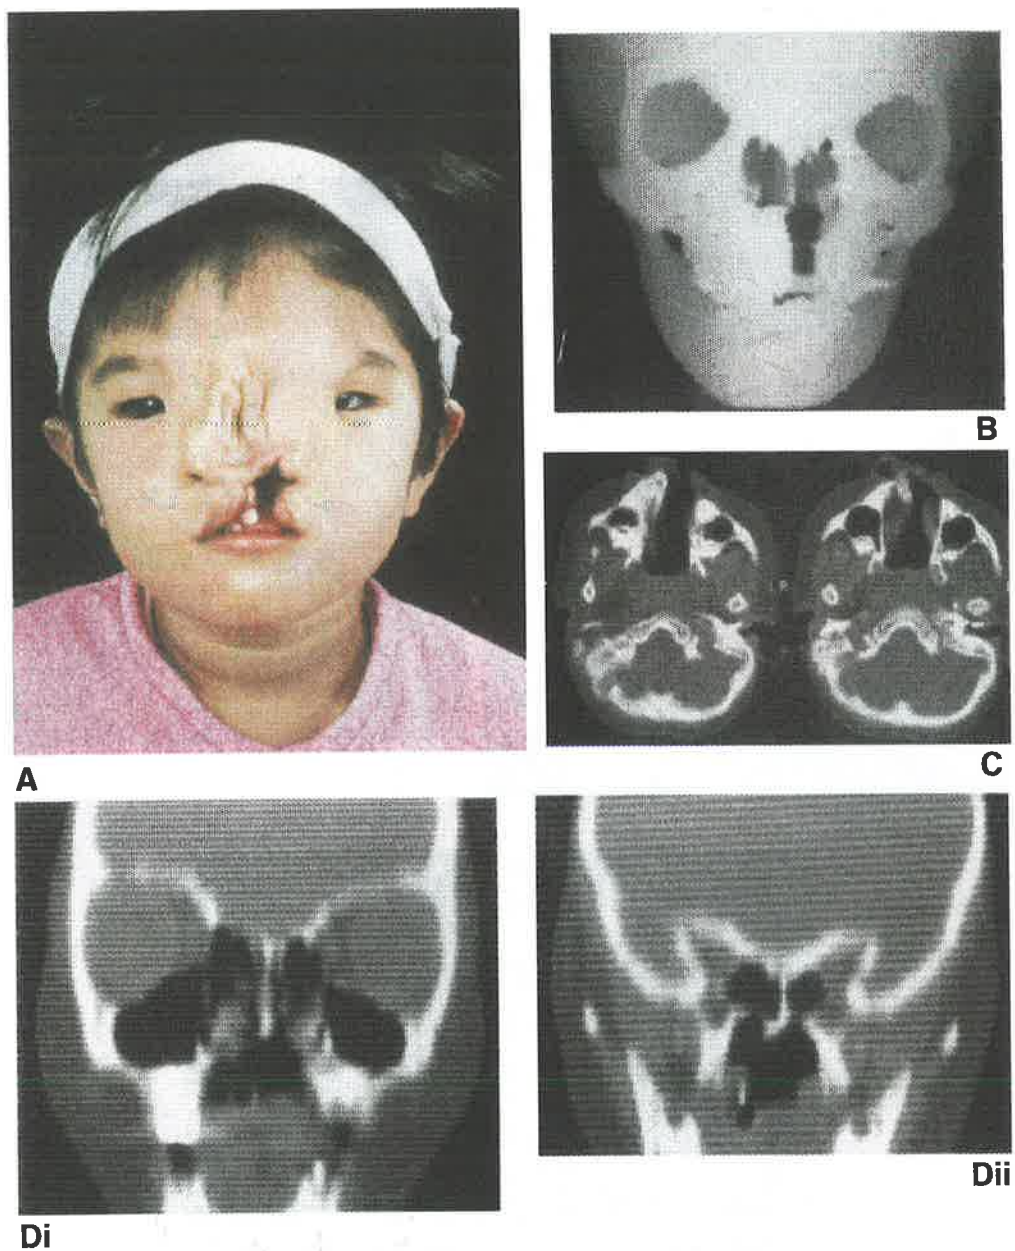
A. Four-year-old Malay Chinese girl with left-sided craniofacial clefts of the Tessier Number 1-13 type. B. Alveolar clefting between the central and lateral incisor extends into the pyriform margin. C. Normal septation between the nasal cavity and the hypoplastic cleft maxilla. D. Coronal two-dimensional CT reformats confirm cleft side maxillary hypoplasia, inferior orbital dislocation, pterygoid plate, and anterior and middle cranial fossa floor asymmetry (i-ii).*
